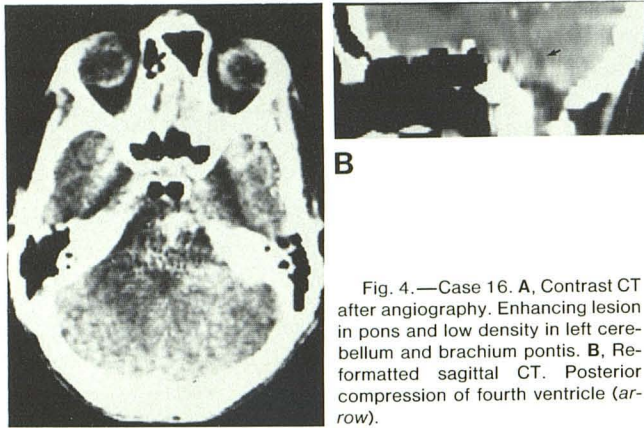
Case 16. A, Contrast CT after angiography. Enhancing lesion in pons and low density in left cerebellum and brachium pontis. B, Reformatted sagittal CT. Posterior compression of fourth ventricle (arrow).
